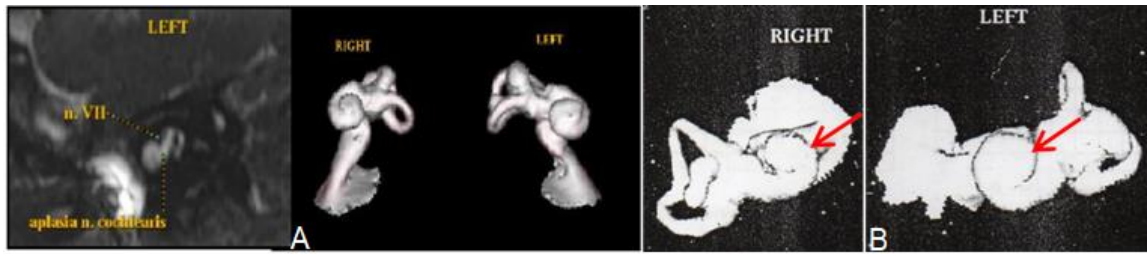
(A) MRI and (B) CT scan result of patient in case 2.
